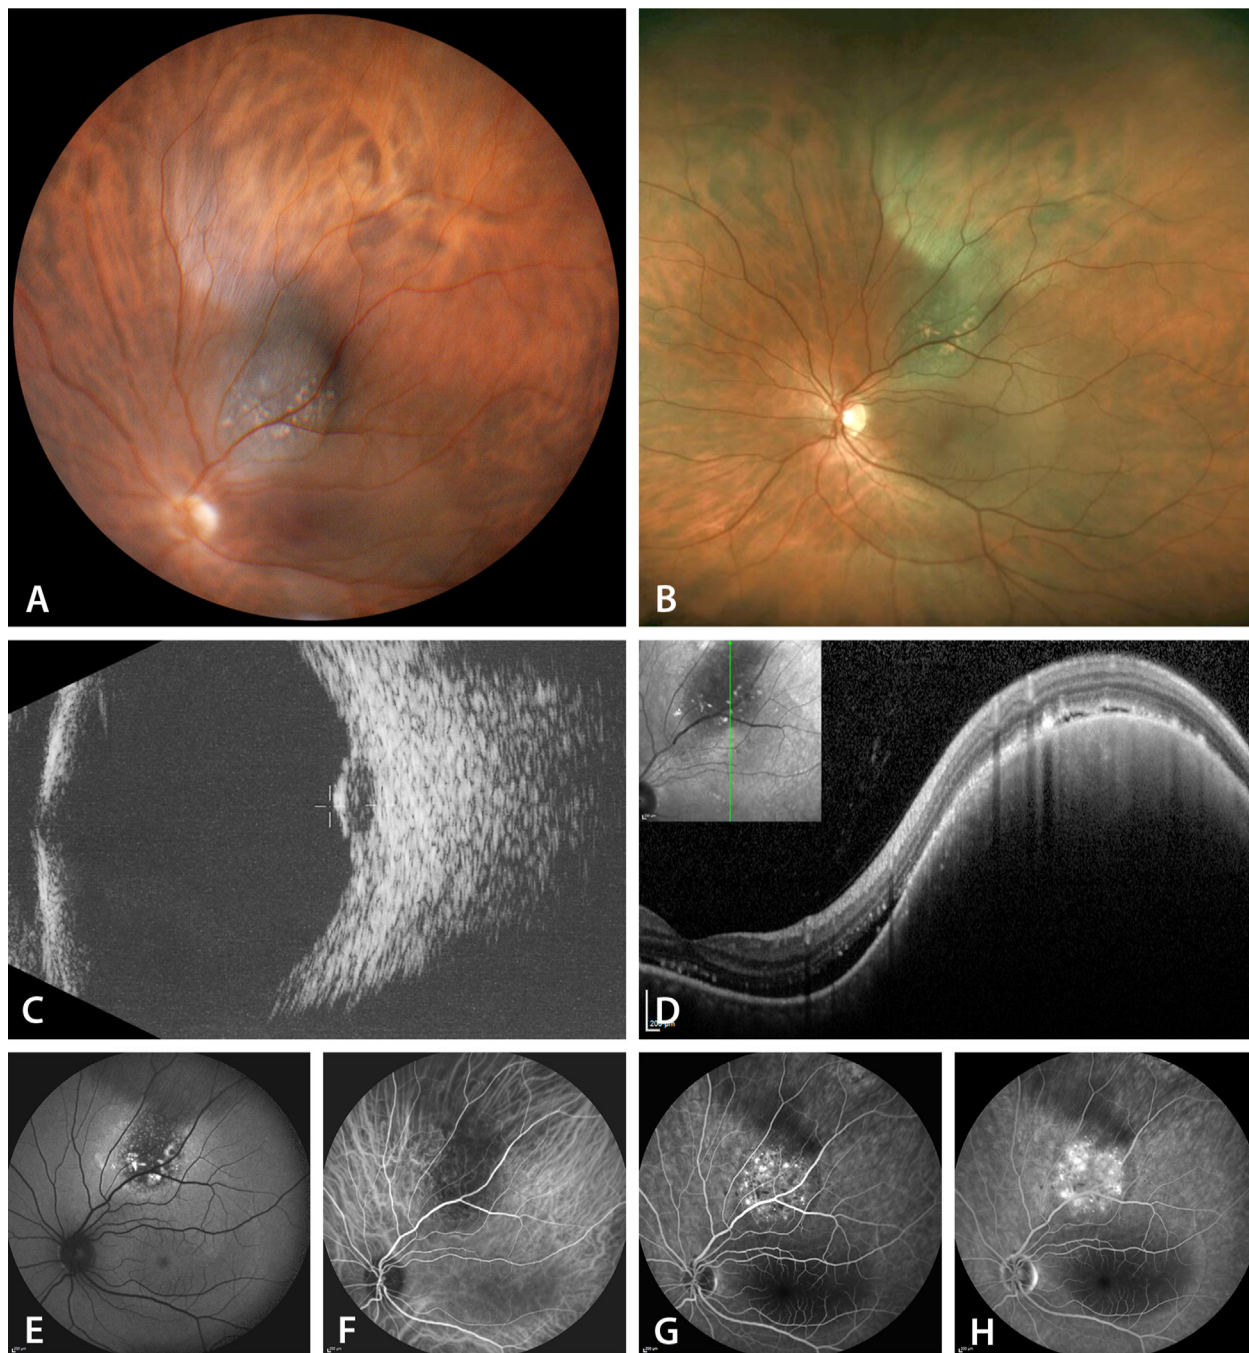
Small choroidal melanoma. (A) Color fundus photography (Panoret-1000, CMT Medical Technologies Inc., Valley Stream, NY) of a small pigmented mass within the supramacular choroid in a 62-year-old male. VA = 0.6. Patient had observed a relative grayish inferior scotoma over the past weeks. (B) Color fundus photography (Optos, PLC, Dunfermline, UK) of the same lesion, at the same day, but with a different camera. A green shade interferes with the actual tumor colors, and its margins are less in contrast with the surrounding choroid. There is also a lesser impression of a three-dimensional lesion (C) on 10 MHz B-scan ultrasonography, the tumor is dome-shaped. $H = 3.0$ mm (D) on B-scan OCT (Heidelberg Engineering spectralis), “shaggy” photoreceptors at the tumor’s surface can be observed. Subretinal fluid surrounds the mass. (E) Orange pigment at the surface appears auto-fluorescent (Heidelberg Engineering spectralis). (F) On ICG-A (Heidelberg Engineering spectralis), the tumor provokes a masking defect. (G) On early FA, the orange pigment appears hypofluorescent. (H) On late FA (Heidelberg Engineering spectralis), the pinpoints, already visible at the early stage, present a progressive diffusion at the surface, causing a macular detachment. FA, fluorescein angiography; H, height; ICG-A, indocyanine green angiography; OCT, optical coherence tomography; VA, visual acuity; VEGF, vascular endothelial growth factor. *Courtesy of Dr A Schalenbourg.*
